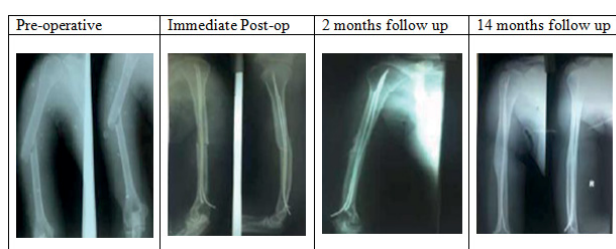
Radiographs of Humeral TENS.
